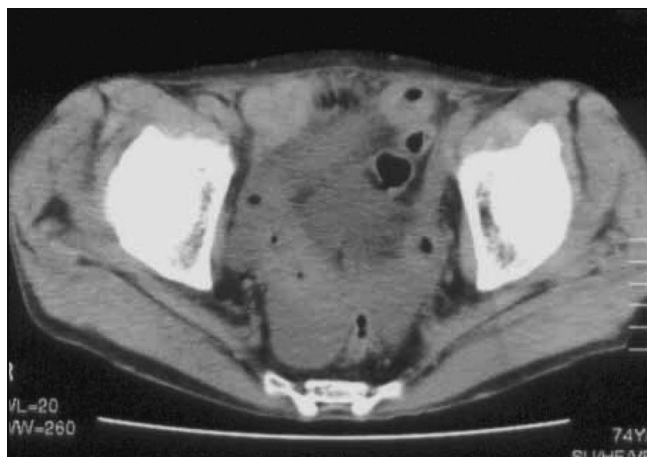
Abdominal CT showing significant edematous change of the ileum (R).
